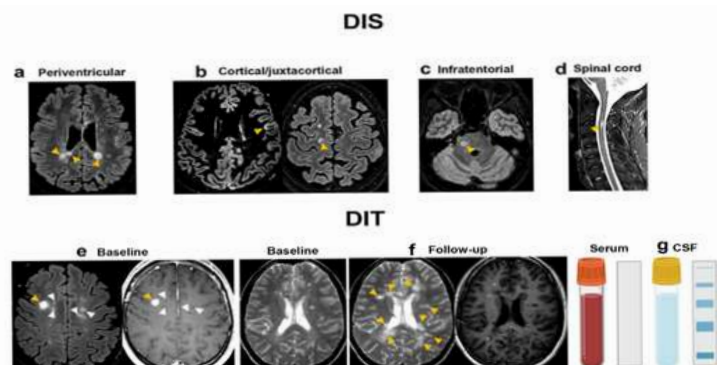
The 2017 McDonald criteria for DIS and DIT manifestation in individuals with a CIS suggestive of MS. Typical MRI examples of (a) periventricular, (b) cortical/juxtacortical, (c) infratentorial, and (d) spinal cord MS lesions (orange arrowheads). ≥ 1 T2 hyperintense lesions in ≥ 2 of the four typical regions of the central nervous system (i.e., periventricular, cortical/juxtacortical, infratentorial, or spinal cord) are indicative of DIS. (e) the simultaneous existence of Gd-enhancing (orange arrowheads) and non-enhancing (white arrowheads) lesions at any time; (f) a new T2-hyperintense and/or Gd-enhancing lesion on a follow-up MRI (orange arrowheads), regardless of when the baseline MRI was performed. The 2017 revision of the McDonald criteria eliminated the distinction between symptomatic and asymptomatic lesions for both DIS and DIT. (g) The demonstration of CSF-specific OCBs, i.e., not present in the serum but only in the CSF, replaces the requirement of fulfilling DIT in patients with a typical CIS suggestive of MS fulfilling DIS criteria and without a better explanation for the clinical presentation, allowing a diagnosis of MS even if the clinical and MRI findings do not meet the criteria for DIT. CIS stands for clinically isolated syndrome; CSF for cerebrospinal fluid; DIS for dissemination in space; DIT for dissemination in time; Gd for gadolinium; MRI for magnetic resonance imaging; and MS for multiple sclerosis.
